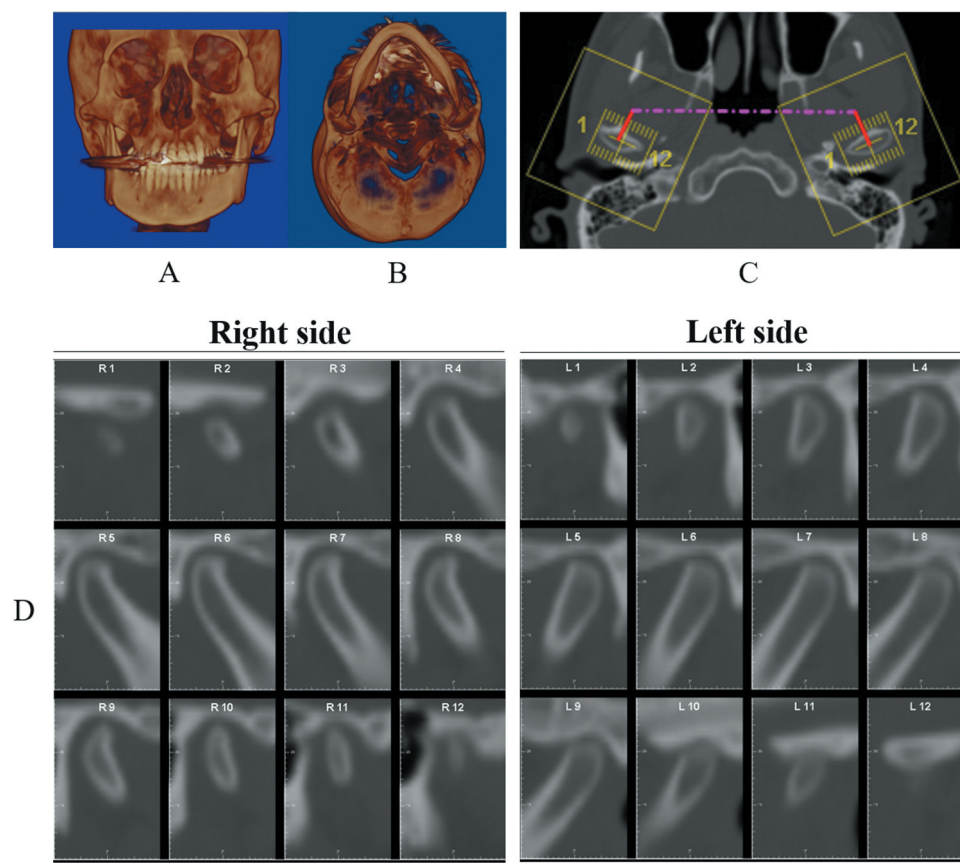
Three-dimensional CT images at pre-treatment (23 years 5 months). (A) Frontal view. (B) Axial view. (C) Serial slices of each condylar head. (D) No findings were observed such as osteoarthritis or subchondral cysts. Scale bar means 10 mm.
